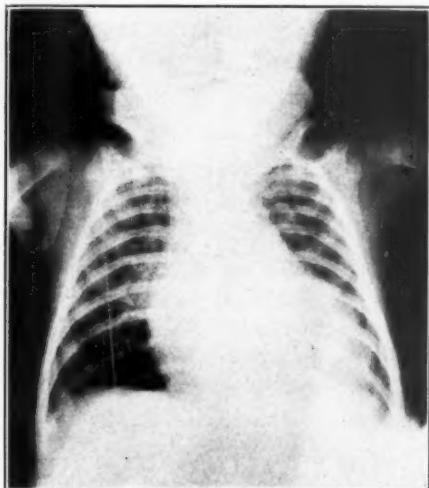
An x-ray film of the chest showing the diffuse cardiac enlargement which was most prominent in the region of the ventricles. The tube distance in this instance was seven feet from the heart.
